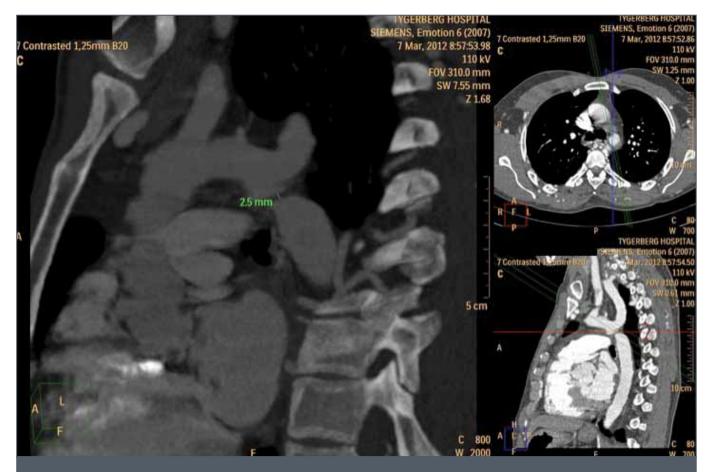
CT demonstrating a 2.5mm interruption of the aortic arch just distal to the left subclavian artery. This suggests IAA Type A.
